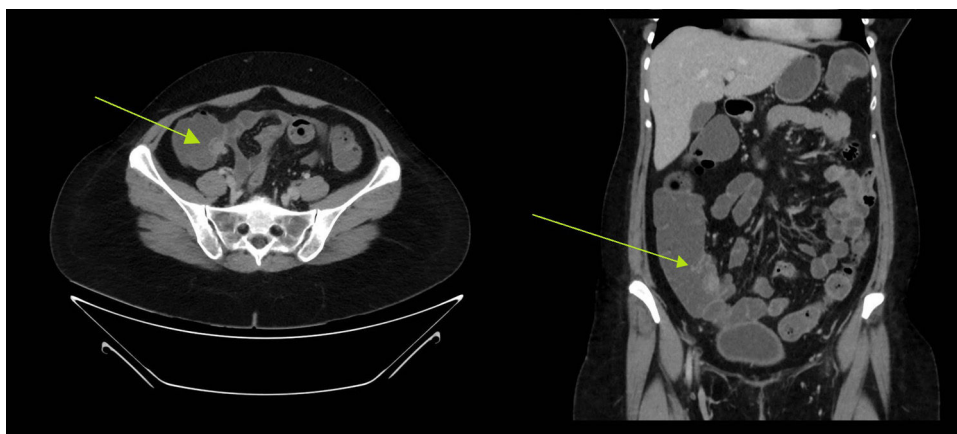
Image of endometriosis mimicking carcinoid lesion in the caecum. Cross-sectional and coronal section of the double-contrast CT scan where a lobular lesion was identified in the caecum adjacent to the ileocaecal valve of approximately 27 × 21 × 20 mm, suggestive of carcinoid tumour lesion. The green arrow is pointing to the lesion.
